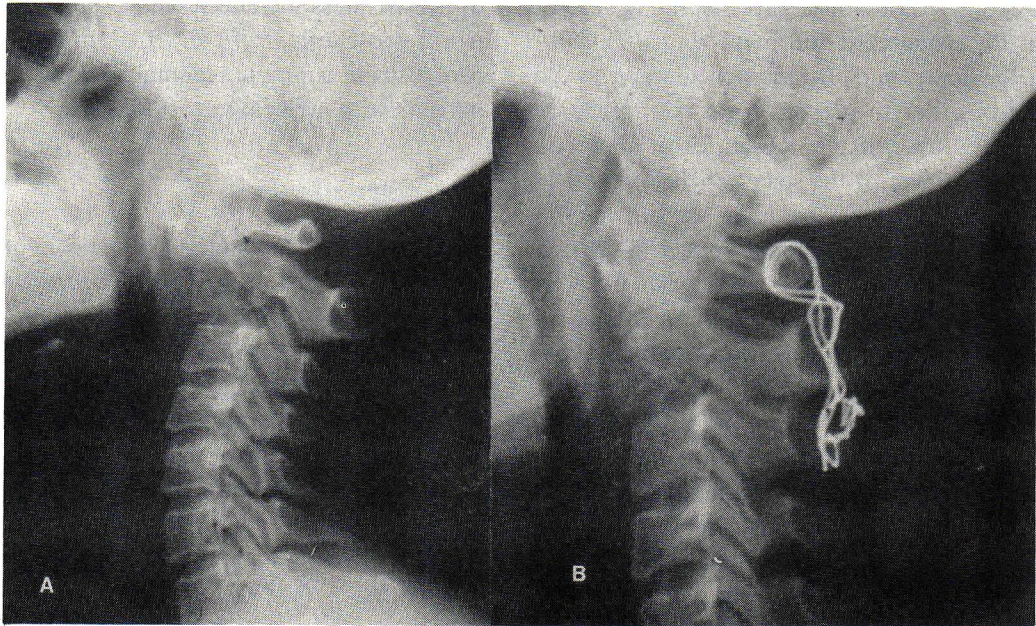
Lateral view of cervical spine x-ray, A. atlanto-axial dislocation
